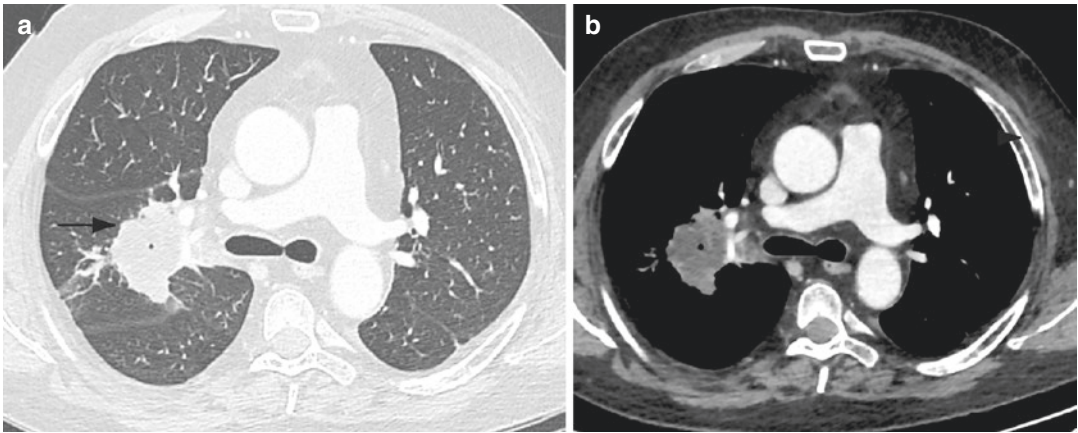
Invasive aspergillosis after transplantation. Axial non-enhanced computed tomography (NECT) of a transplanted patient with invasive aspergillosis shows a
